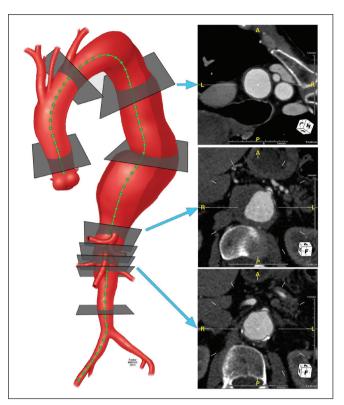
Computed tomography angiography analysis in patients with complex aortic aneurysms include three-dimensional reconstructions and centerline of flow measurements. Axial imaging is used for vessel diameter measurements and vessel location in relation to clock position. By permission of Mayo Foundation for Medical Education and Research. All rights reserved.
